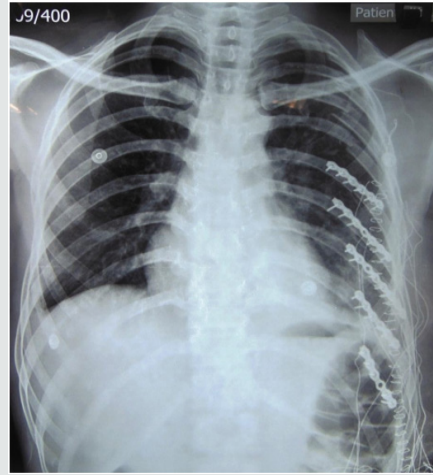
Postoperative radiograph showing surgical fixation of 6th to 10th ribs.
